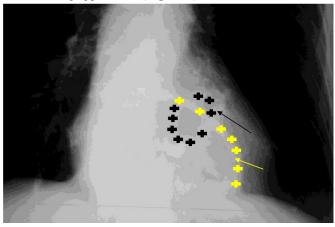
Frontal chest x-ray: Image evoking a Chinese ring formed by the intersection of the calcified mitral annulus (black arrow, drawn by black plus sign) and an annulus formed by a large hiatal hernia (yellow arrow, drawn by yellow plus sign).
